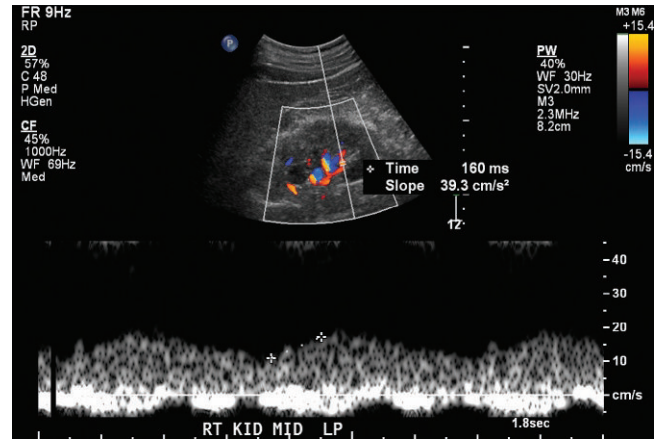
Spectral Doppler of right lower pole intrarenal artery. There is a tardus parvus waveform. The time to peak systole is delayed, 160 ms. There is little difference between systole and diastole. The findings indicate upstream obstruction is bilateral. This can be due to bilateral renal artery stenosis or obstruction higher up in the circulation, such as the aorta.
